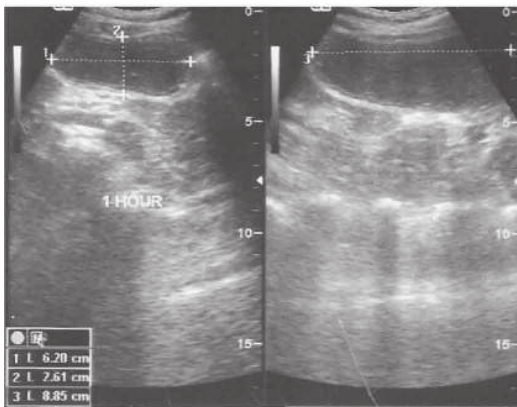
Ultrasound images of the stomach and volume calculation.
